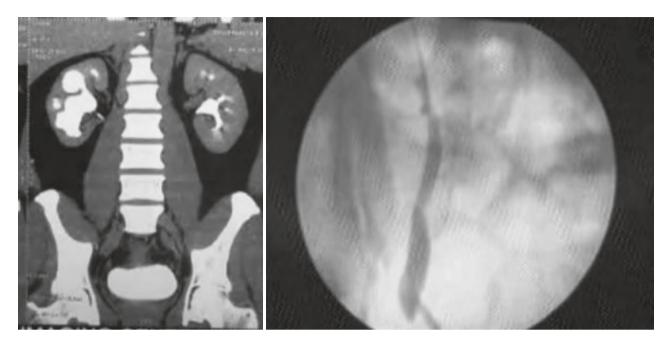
CT showing UPJ obstruction with intra reanal pelvis. RGP shows long segment upper ureteric narrowing
